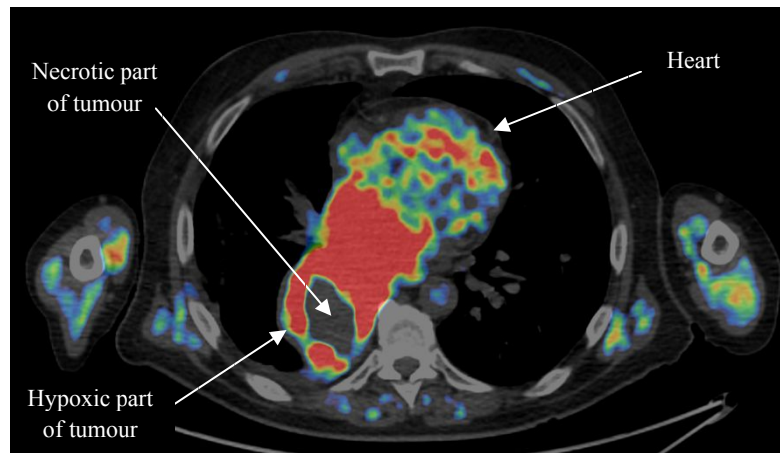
Example four hour FMISO image (from Patient 2_{preC1}) showing no uptake in necrotic part of the tumour (shown to be necrotic in prior CT imaging), using a TBR colour scale 1-1.4.
